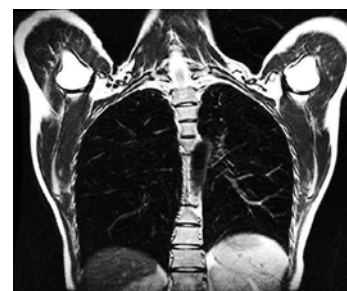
Sagittal section on MRI chest at 36 months shows clear lung parenchyma. No local or nodal recurrence.
